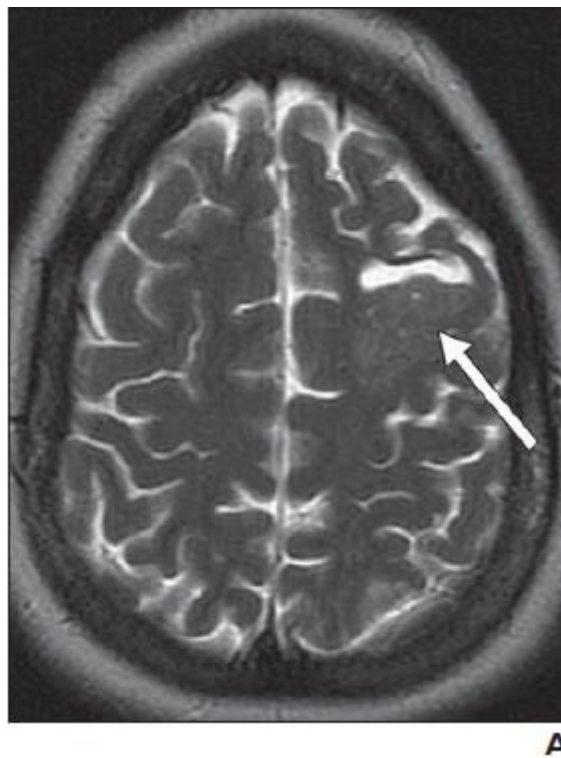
A 25-year-old woman with epilepsy. Axial T2-weighted MR image shows T2-hyperintense cortical thickening in the left frontal lobe with adjacent white matter cystic change (*arrow*). Imaging findings may reflect cortical dysplasia or low-grade neoplasm. Biopsy results revealing gliosis were deemed to reflect nonrepresentative sampling(6,7).
